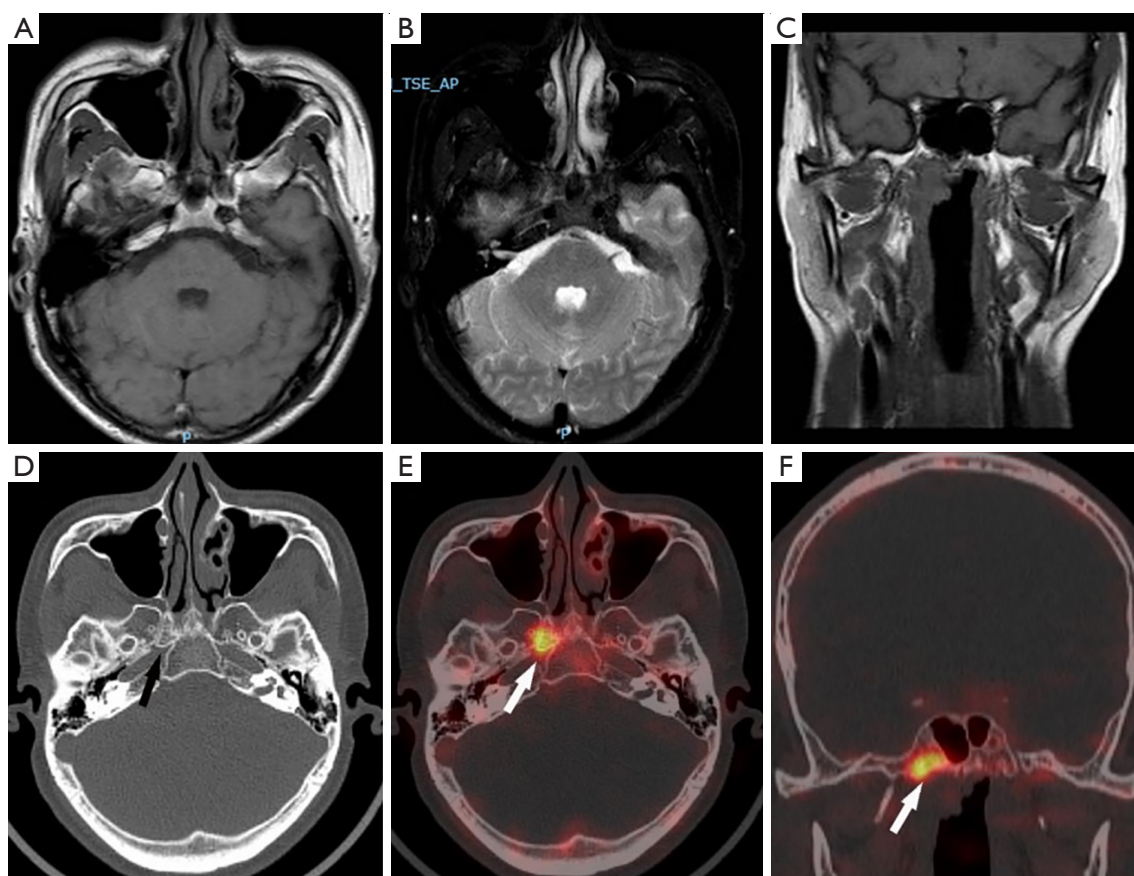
Images of a 29-year-old male patient with NPC. (A) MRI-T1WI, (B) T2WI, and (C) coronal T1WI exhibited no abnormal signals in the skull-base bone. (D) CT imaging (arrow) revealed no discernible bone destruction in the greater wing of the right sphenoid bone. However, (E,F) the ^{18}F -NaF PET/CT fusion images clearly delineated hypermetabolism at the corresponding site, as highlighted by the arrows, confirming the invasion of NPC. Hence, the integrated use of ^{18}F -NaF PET/CT with MRI was pivotal in diagnosing SBBI. NPC, nasopharyngeal carcinoma; MRI, magnetic resonance imaging; T1WI, T1-weighted imaging; T2WI, T2-weighted imaging; CT, computed tomography; ^{18}F -NaF PET/CT, ^{18}F -sodium fluoride positron emission tomography-computed tomography; SBBI, skull-base bone invasion.
